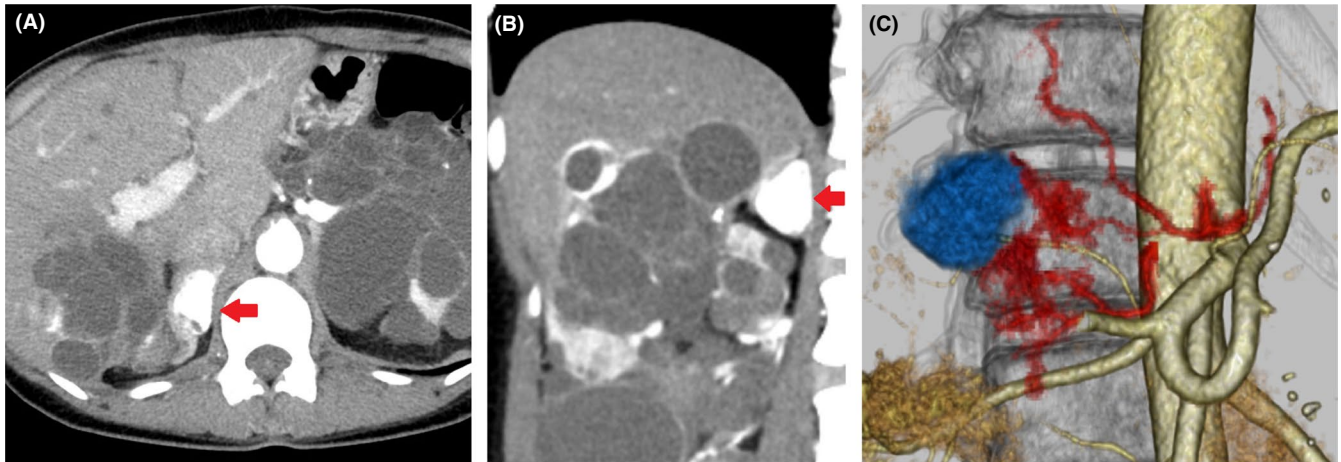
A, Contrast-enhanced CT early phase axial image. B, Contrast-enhanced CT early phase coronal image. C, Contrast-enhanced CT early phase 3D image. Axial contrast-enhanced CT demonstrates a well-enhanced mass (arrow) measuring 2.8 cm in maximum diameter in the right adrenal gland (A). No obvious invasion to the surroundings is observed even in the coronal image (B). 3D image shows left superior adrenal artery and left middle adrenal artery are the feeding vessels (C)
